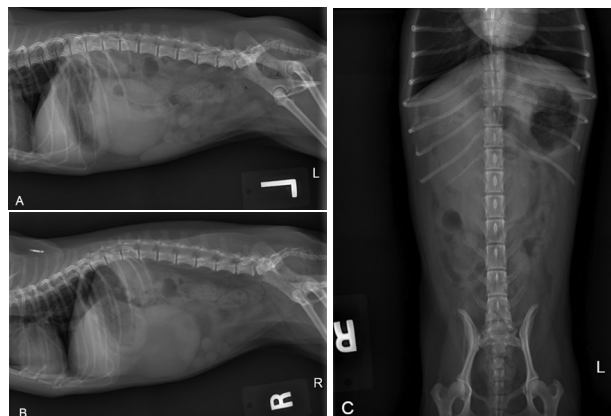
Left lateral (A), right lateral (B), and ventrodorsal (C) radiographic images of an 11-year-old 2.2-kg spayed female Chihuahua referred because of a 1-day history of signs of abdominal pain and decreased appetite.
